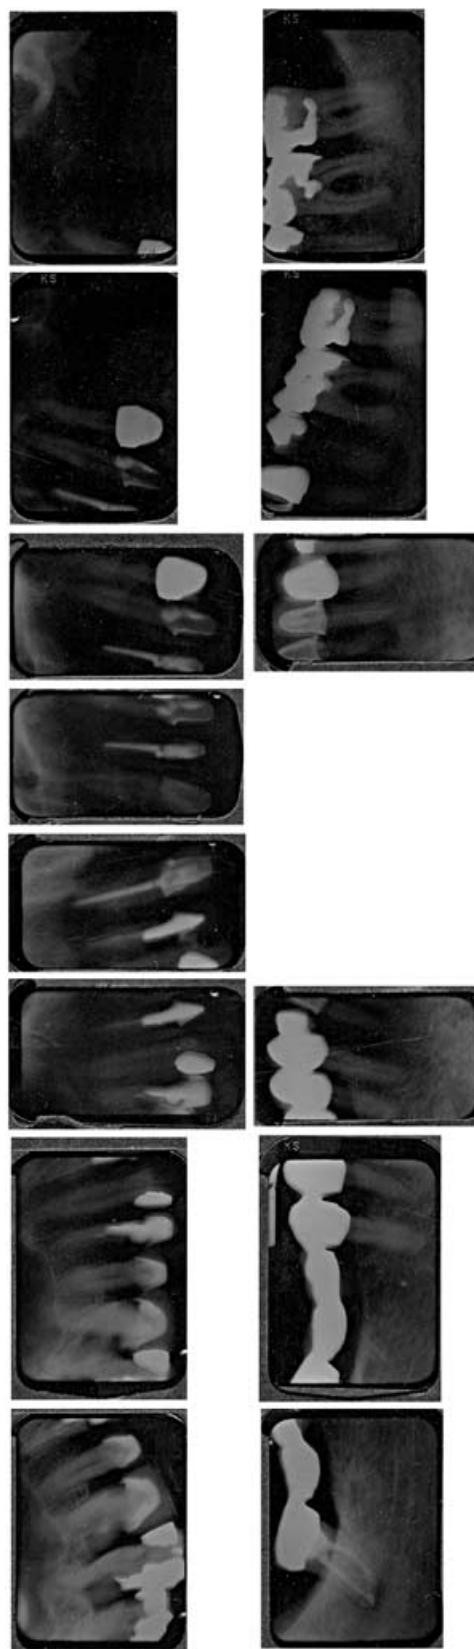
Preoperative periapical radiographs demonstrate advanced bone loss, recurrent caries, multiple missing teeth, and widened periodontal ligaments (1974).
